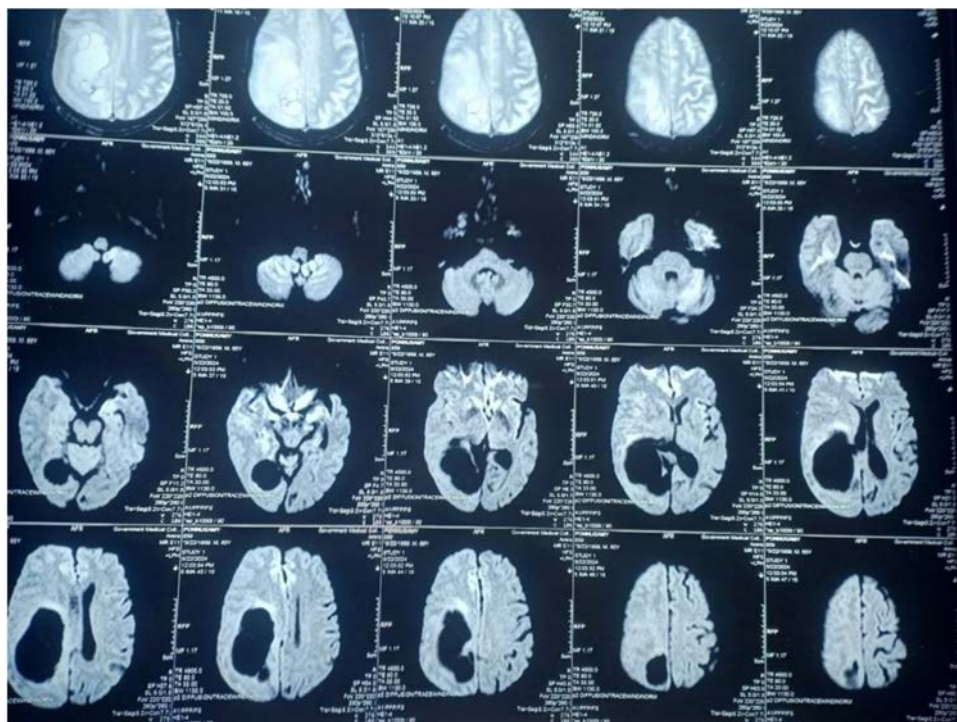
MRI Brain T2W images show multiple cystic space-occupying lesions.
